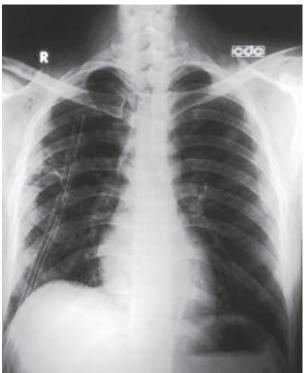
CT* scan of chest showing right-sided pulmonary oedema.
